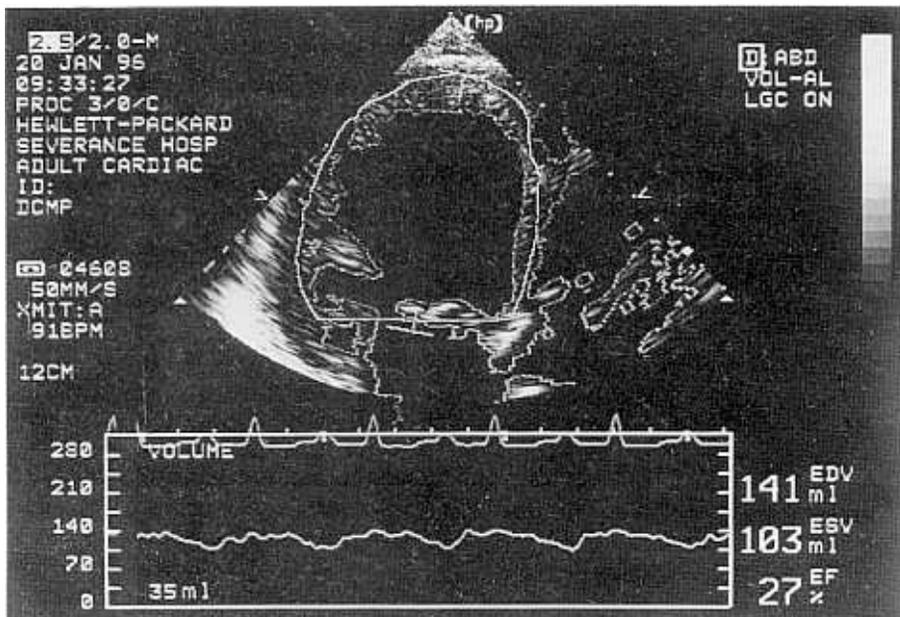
Automatic boundary detection image of apical four chamber view with the region of interest drawn around the left ventricular cavity. The graphs on the bottom demonstrate the instantaneously measured and displayed cavity volume and ejection fraction computed beat by beat.
